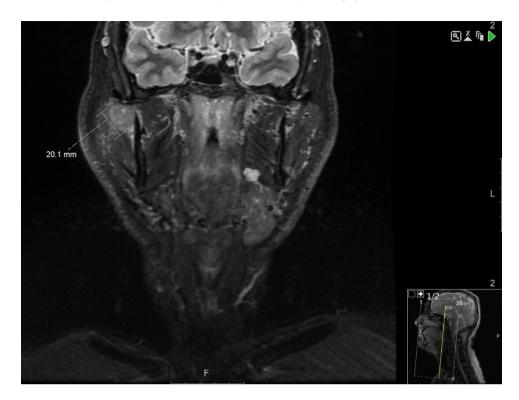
Coronal slice from magnetic resonance image showing a 20 mm lesion that abuts the posterior aspect of the right masseter and contacts the lateral surface of the mandible.
